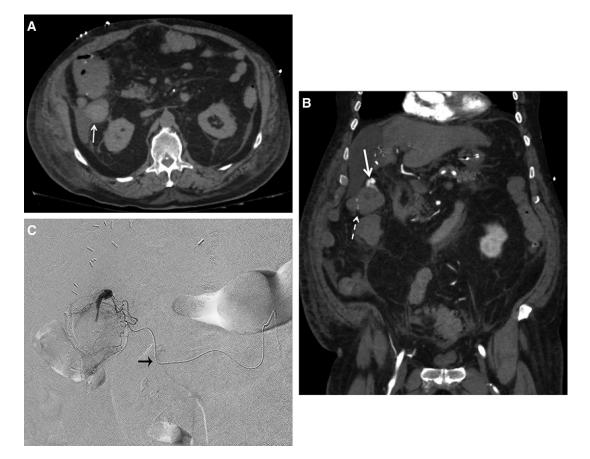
Diverticular hemorrage from transverse post-right hemicolectomy, diagnosed with computed tomography (CT) and treated by embolization. (A) Axial unenhanced CT image shows dense material in distal small bowel (arrow), proximal to ileocolic anastamosis. (B) Coronal arterial phase CT showing active extravasation into colonic diverticulum (solid arrow). Note the surgical staple line (dashed arrow). The CT findings suggest a middle colic branch as the source of bleeding. (C)Superselective distal middle colic arteriogram via a microcatheter (arrow), confirming active extravasation. Rapid selection of bleeding artery was facilitated by prior CT angiography. This vessel was then embolized (images not shown).
